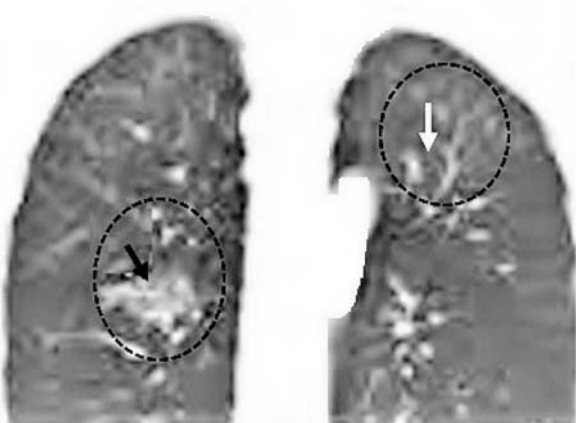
Representative chest magnetic resonance imaging (axial T1-weighted) scan. A 42-year-old male patient with leukemia presenting with multiple masses. The white arrow indicates the homogeneous hypointense signal to a bright area while the black arrow indicates the heterogeneous hypointense signal in the bronchus.
